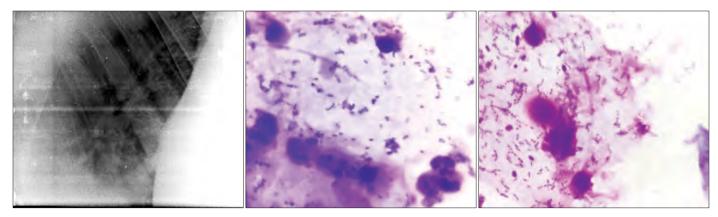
(1) Thoracic radiography indicating unstructural interstitial pattern; (2) Cytological evaluation of TTW showing cellular reaction with presence of degenerated and intact neutrophils, macrophages, lymphocytes along with bacterias; (3) Cytological smears of TTW showing presence of degenerated and intact neutrophils along with numerous rods and coccobacilli (in chains)
